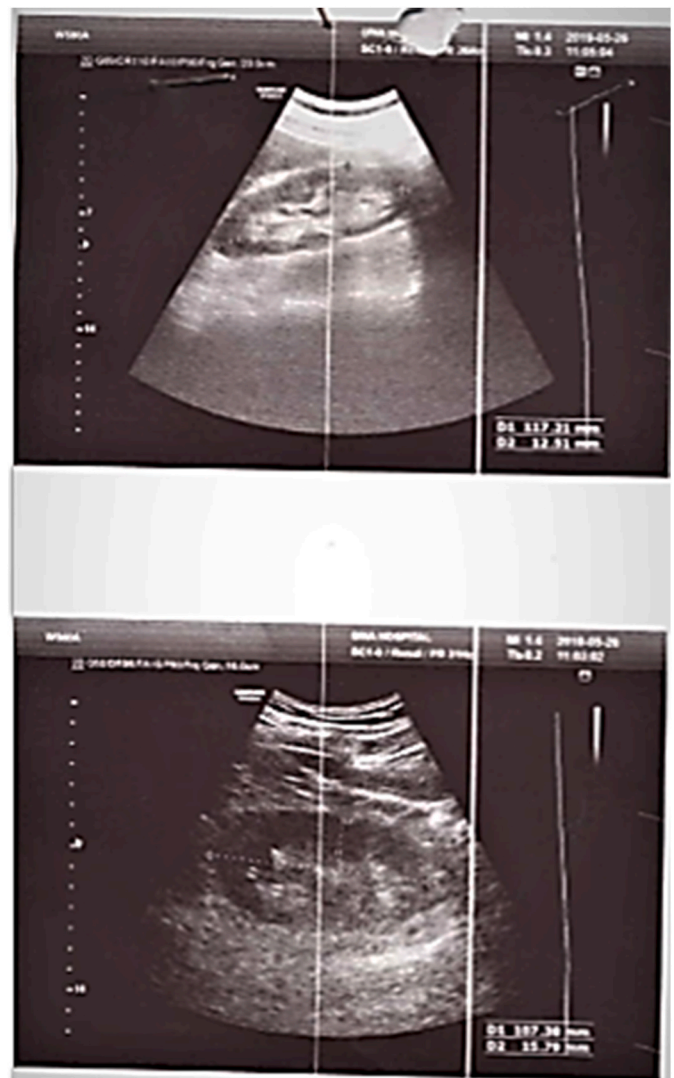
Follow-up sonography.
